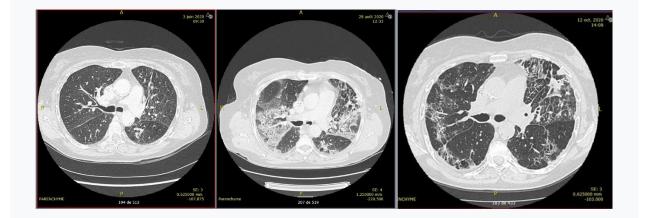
Parenchymal CT scan of Patient 2 before treatment with osimertinib (day 1), before anti-pneumocystis treatment (day 86), and after anti-pneumocystis treatment (day 131).
